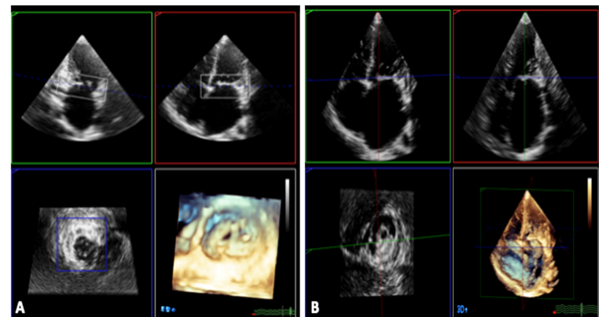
(A) 3-Dimensional echocardiography showing enface view of the mitral valve and MVA after i-cropping and (B) showing MVA exactly at the tips of mitral leaflets by adjusting the image.
